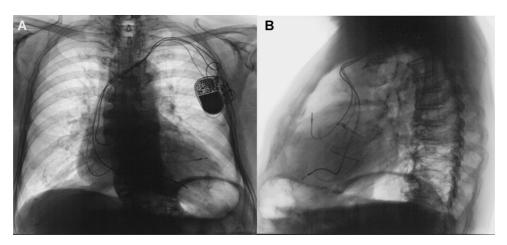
Postoperative chest x-ray from anteroposterior projection (A) and lateral projection (B) after transceptal left ventricular pacing lead implantation.
